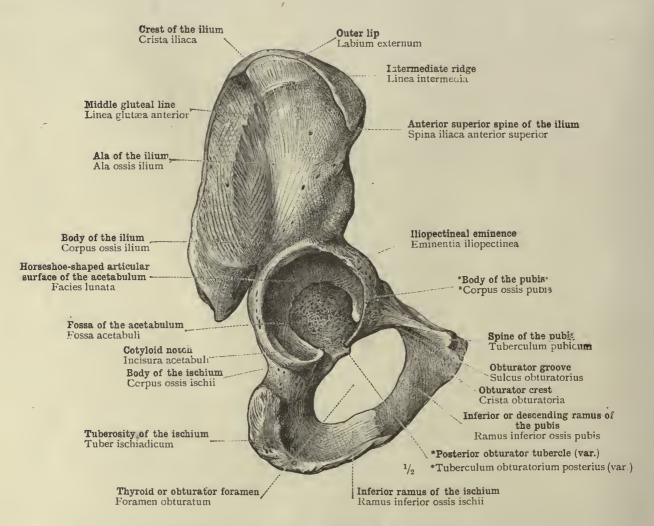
THE RIGHT HIP-BONE, OUTER SIDE. POSTERIOR ASPECT.
